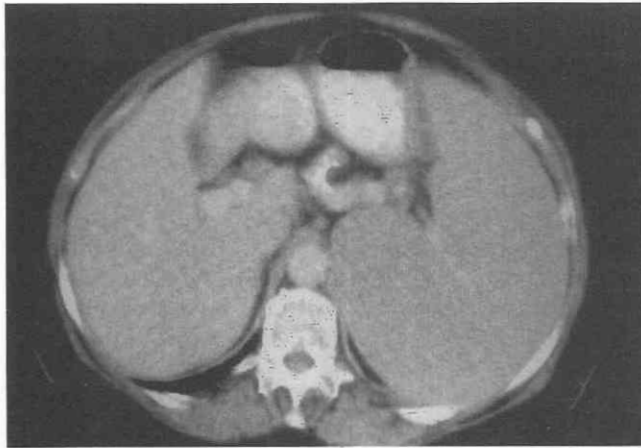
This CT scan reveals massive splenomegaly in a patient with non-Hodgkin's lymphoma.
